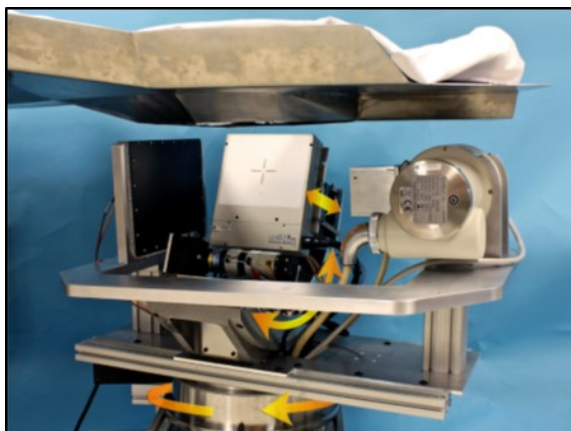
Photograph of the hybrid SPECT/CT breast imaging system. Patient lie in an prone position with the breast suspended in air. The gamma camera follows a path that contours to the breast shape. Picture reproduced from Cutler et al. (2010).
